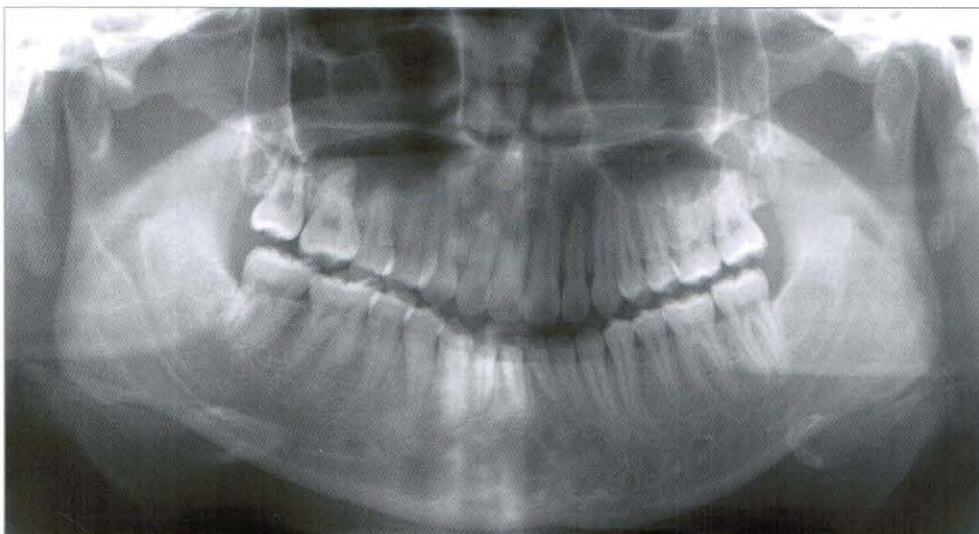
Panoramic radiograph at debonding (2007, 3,22)
